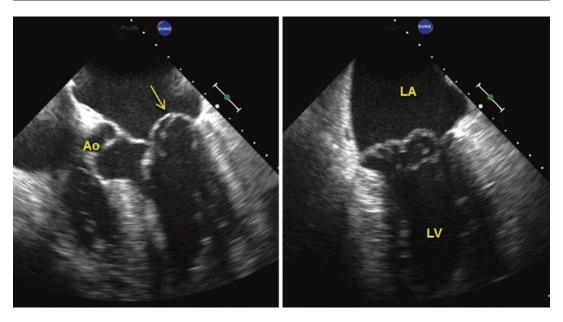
Transesophageal echocardiograms in the three-chamber (left panel) and two-chamber (right panel) views showing obvious prolapse (arrow) of the P2 segment. The images were obtained prior to mitral valve replacement
